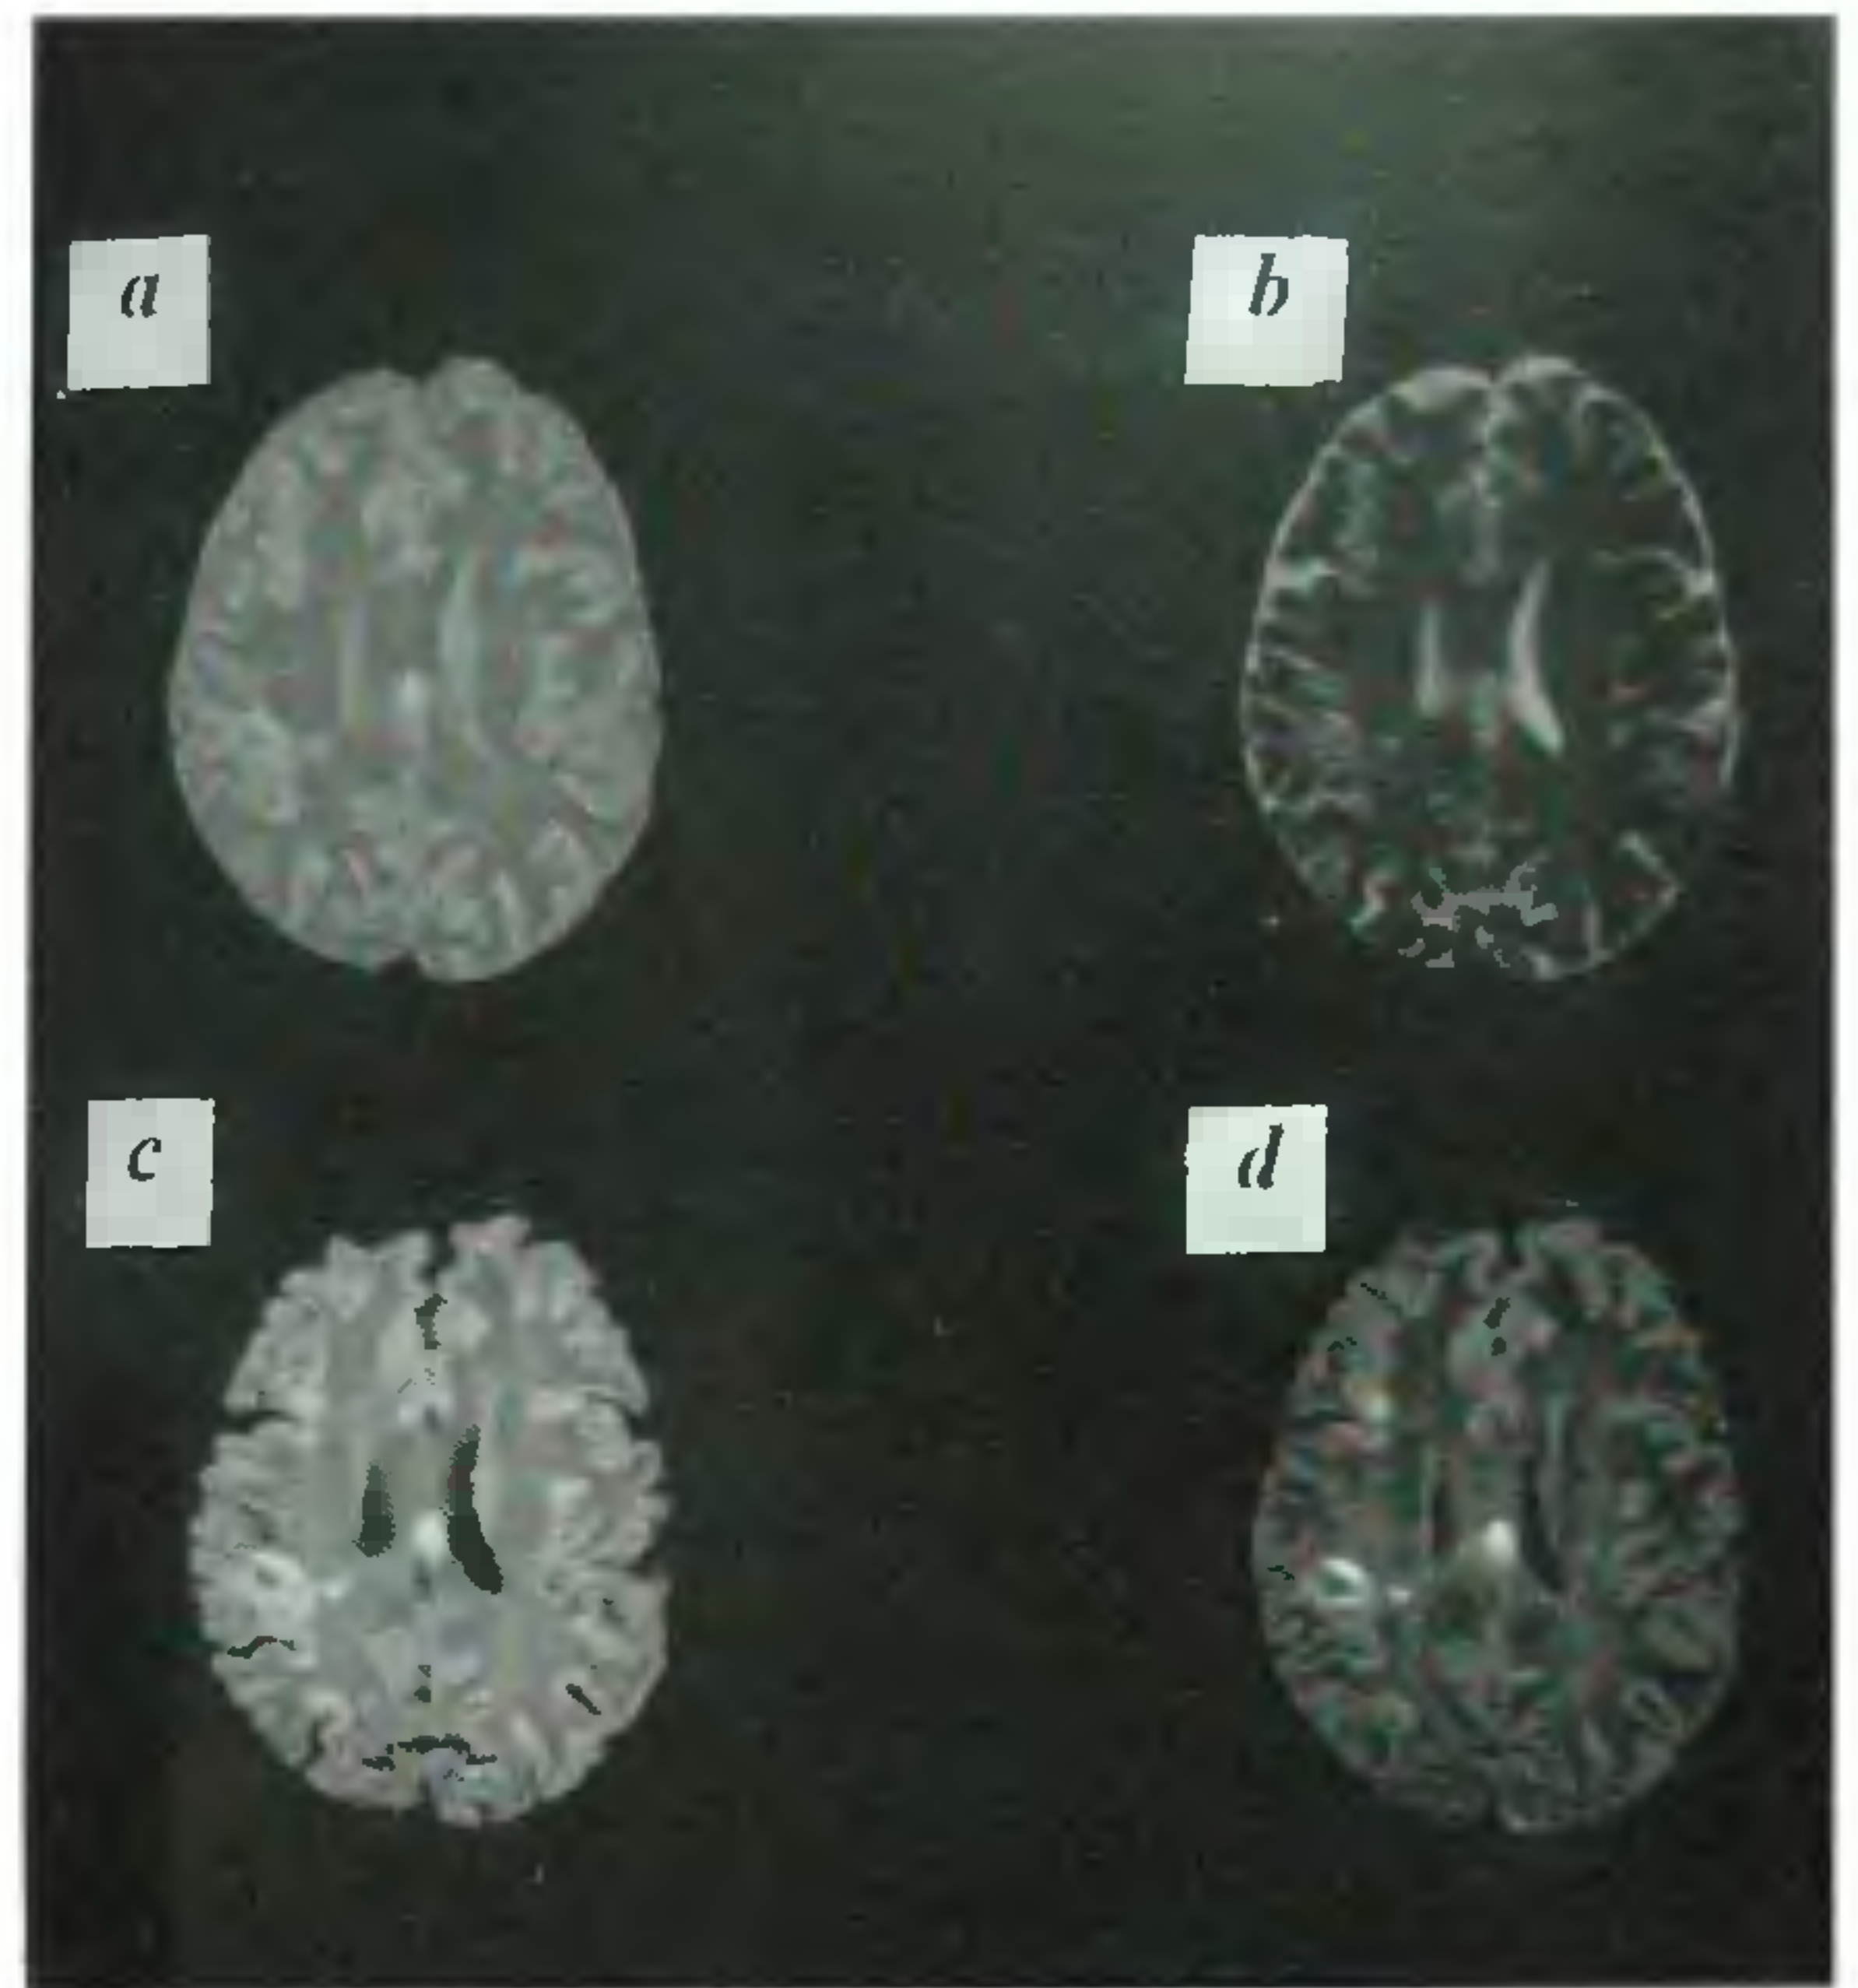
Axial images of a MS brain acquired with the AFFIRMATIVE sequence. *a*, FSE image with TE = 17 ms; *b*, FSE image with TE = 102 ms; *c*, FLAIR/MTC image with TE = 17 ms; and *d*, FLAIR/MTC image with TE = 102 ms. The other imaging parameters are: TE = 10,000 ms, slice thickness = 3 mm, field-of-view = 240 mm, acquisition matrix of 256 × 128 (image matrix of 256 × 256), number of excitations = 1. The clear visualization of cortical and sub-cortical lesions in the late echo FLAIR/MTC image, *d*, compared to the FSE images can easily be appreciated. (Reprinted from ref. 45 with permission).
